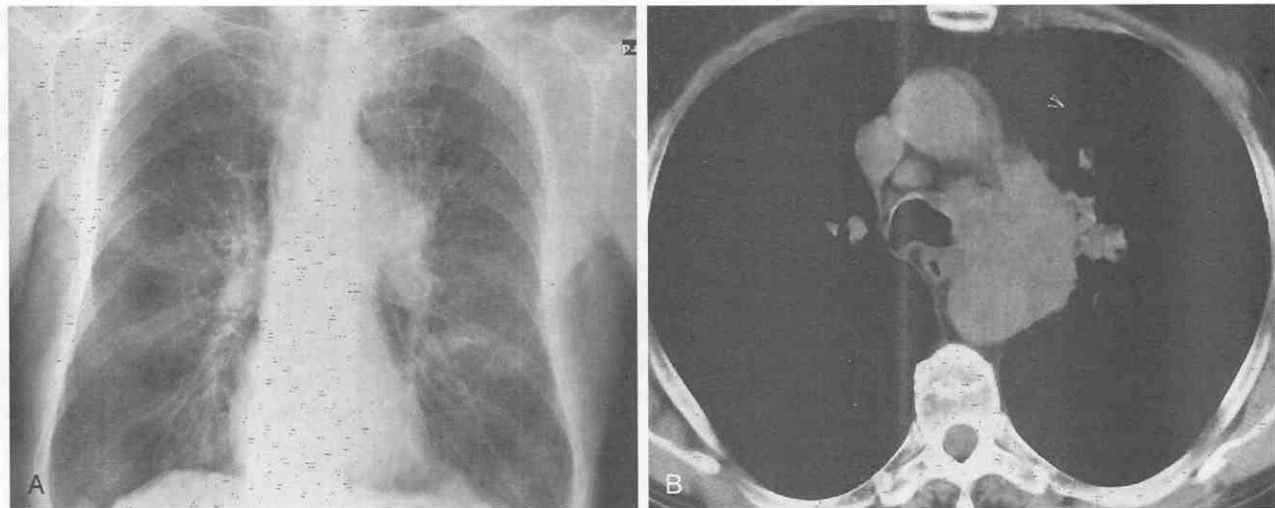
Small-cell lung cancer in a 76-year-old man presenting with hoarseness caused by involvement of the recurrent laryngeal nerve. *A*, Posteroanterior chest radiograph shows an aortopulmonary window mass. *B*, CT reveals mediastinal invasion with an extension of the mass into the aortopulmonary window (the anatomic location of recurrent laryngeal nerve).
